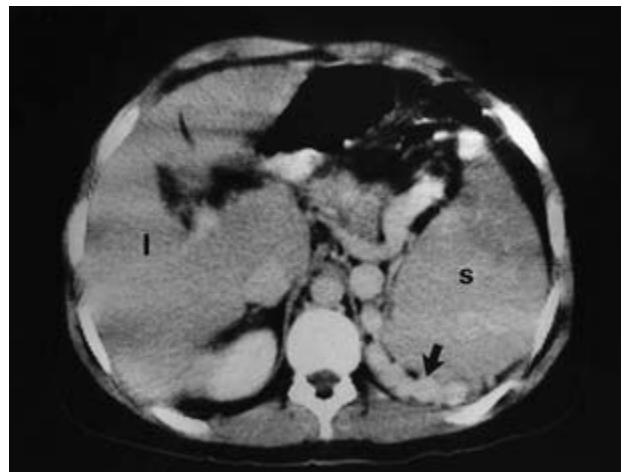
Contrast-enhanced CT scan in a patient with cirrhosis and a large retroperitoneal retrosplenic collateral circulation (arrow). l, liver; s, spleen.
